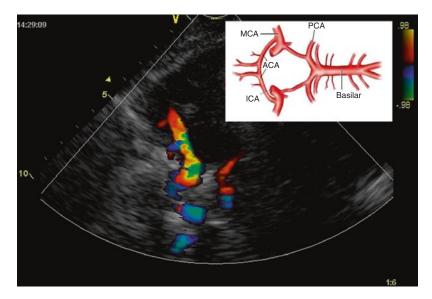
Typical transcranial color-coded duplex sonography (TCCS) view of the circle of Willis
